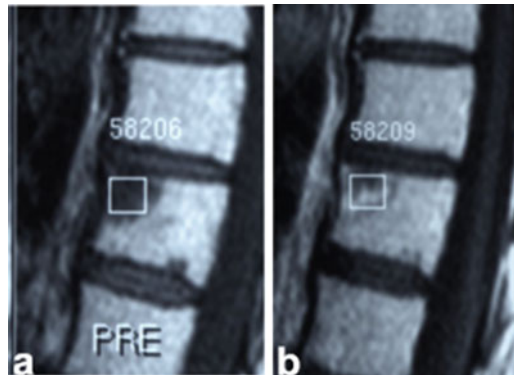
Sagittal MRI images (T1TSE sequence) showing bone metastasis in the eighth thoracic vertebra in a patient with lung carcinoma. Before treatment (a) a low signal intensity was evident (b) that was significantly enhanced after Gd administration (This figure is reprinted from the book *Bone Metastases: A translational and clinical approach*, chapter 17: Assessment of therapeutic response pages 344–370, figure 17.3, copyright 2009, after a kind permission of Springer Science and Business Media B.V.)
